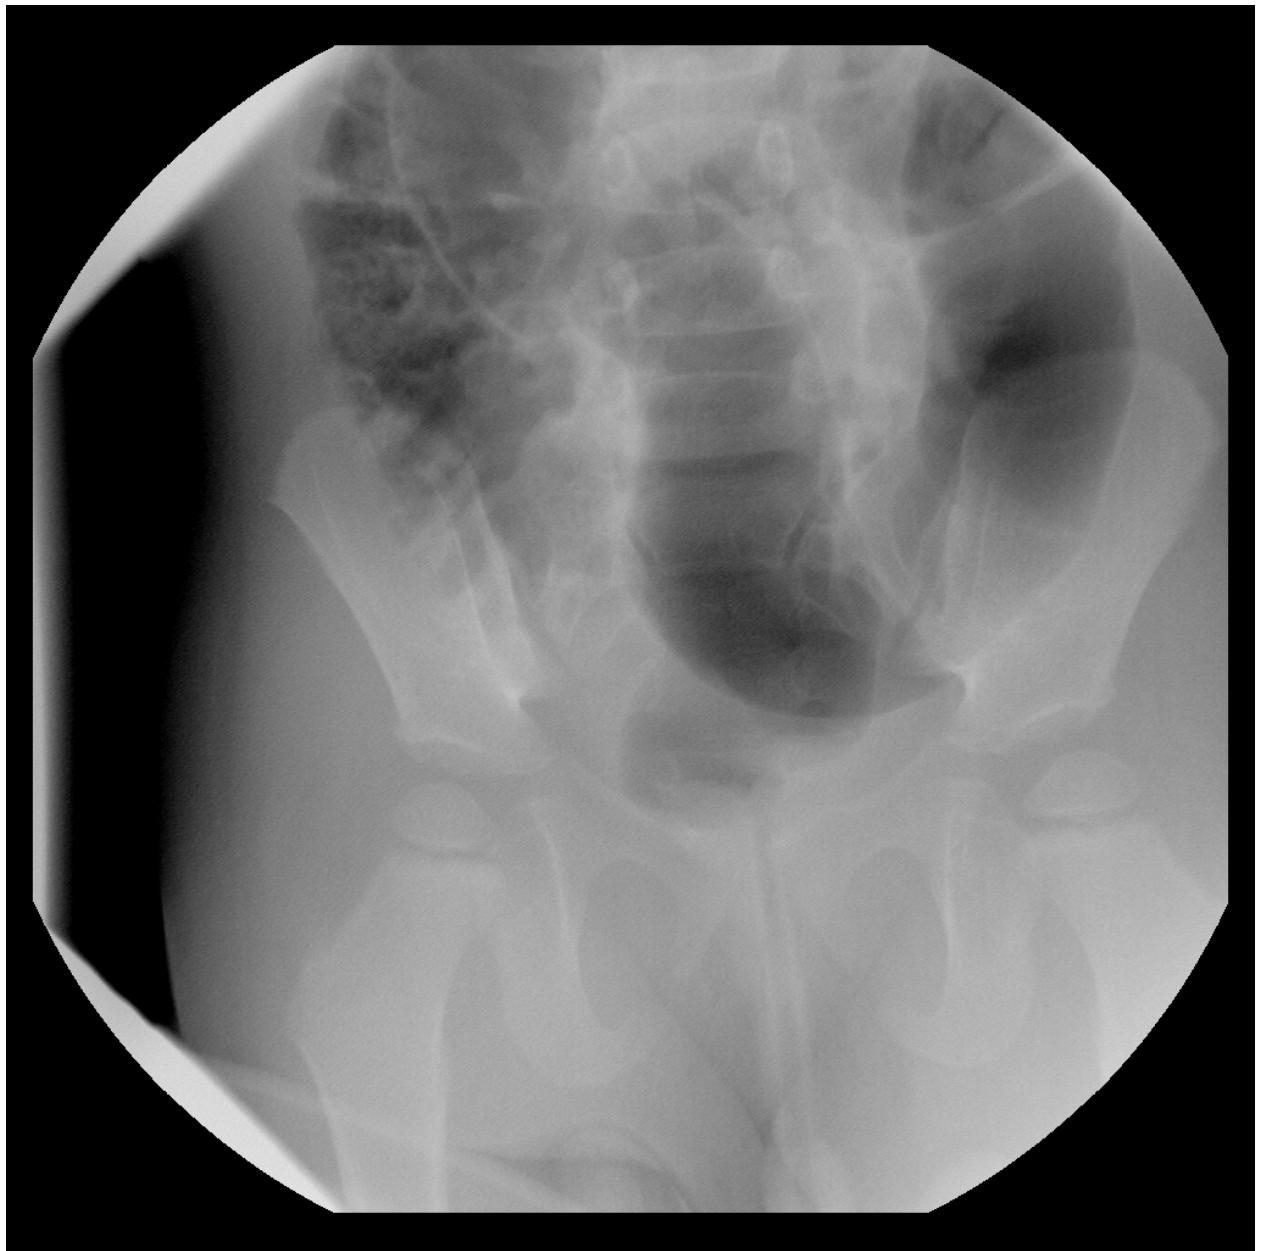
Emily – initial radiograph. Note the gas and stool in the expected location of the cecum.
